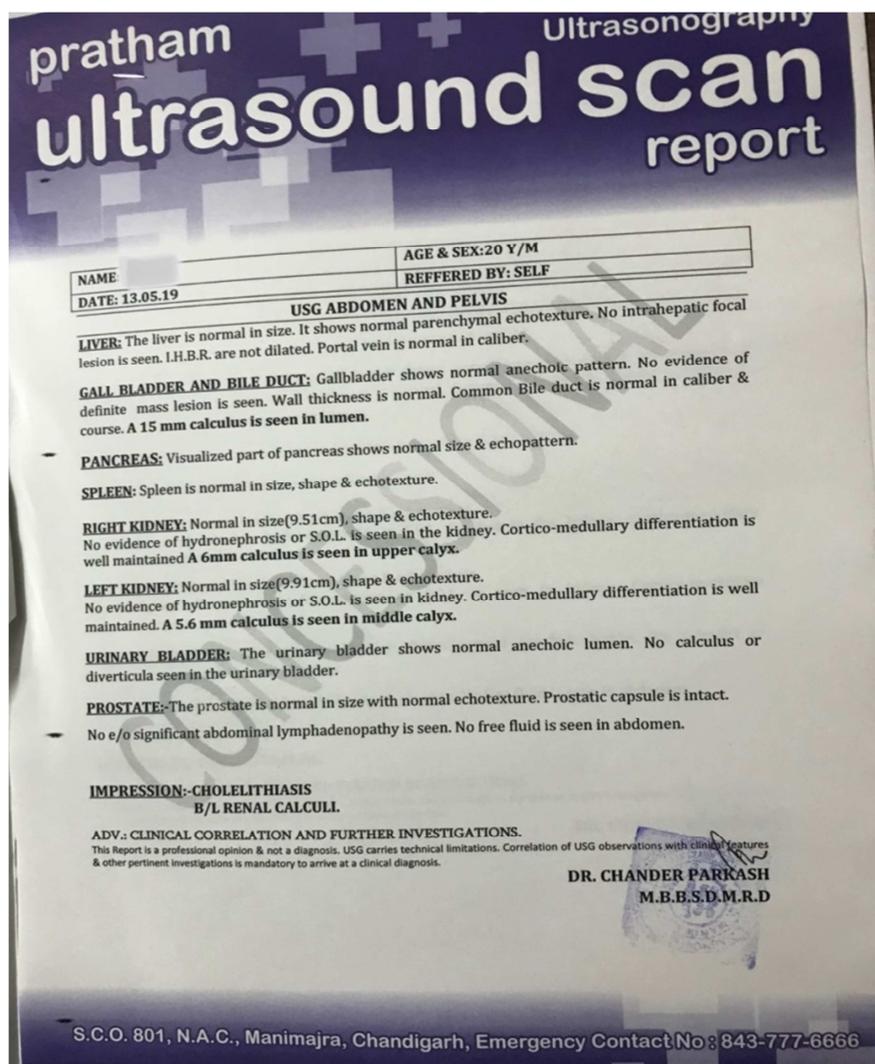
Ultrasound of the patient showing 15 mm of gallstone.
